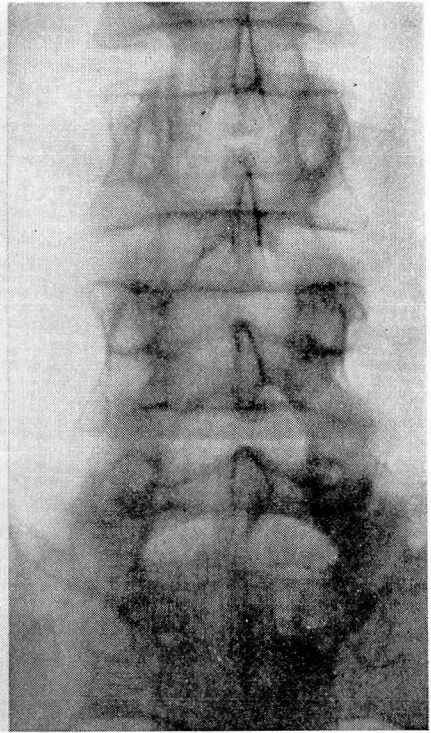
Roentgenogram made after forced spinal drainage with recovery of 90 per cent of the injected thorotrast.
